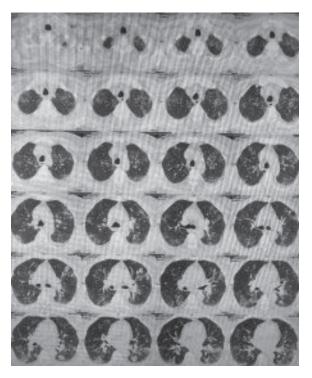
High resolution computed tomography (HRCT) scan of chest showing fibrous bands with multiple ground glass density involving 60-65% of lung volume
